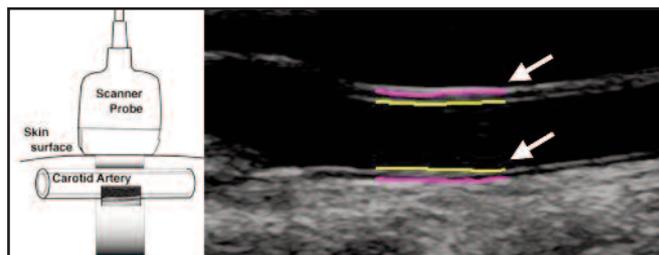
Ultrasound scan of the common carotid artery (left) and measurement of CIMT (right, arrows).
